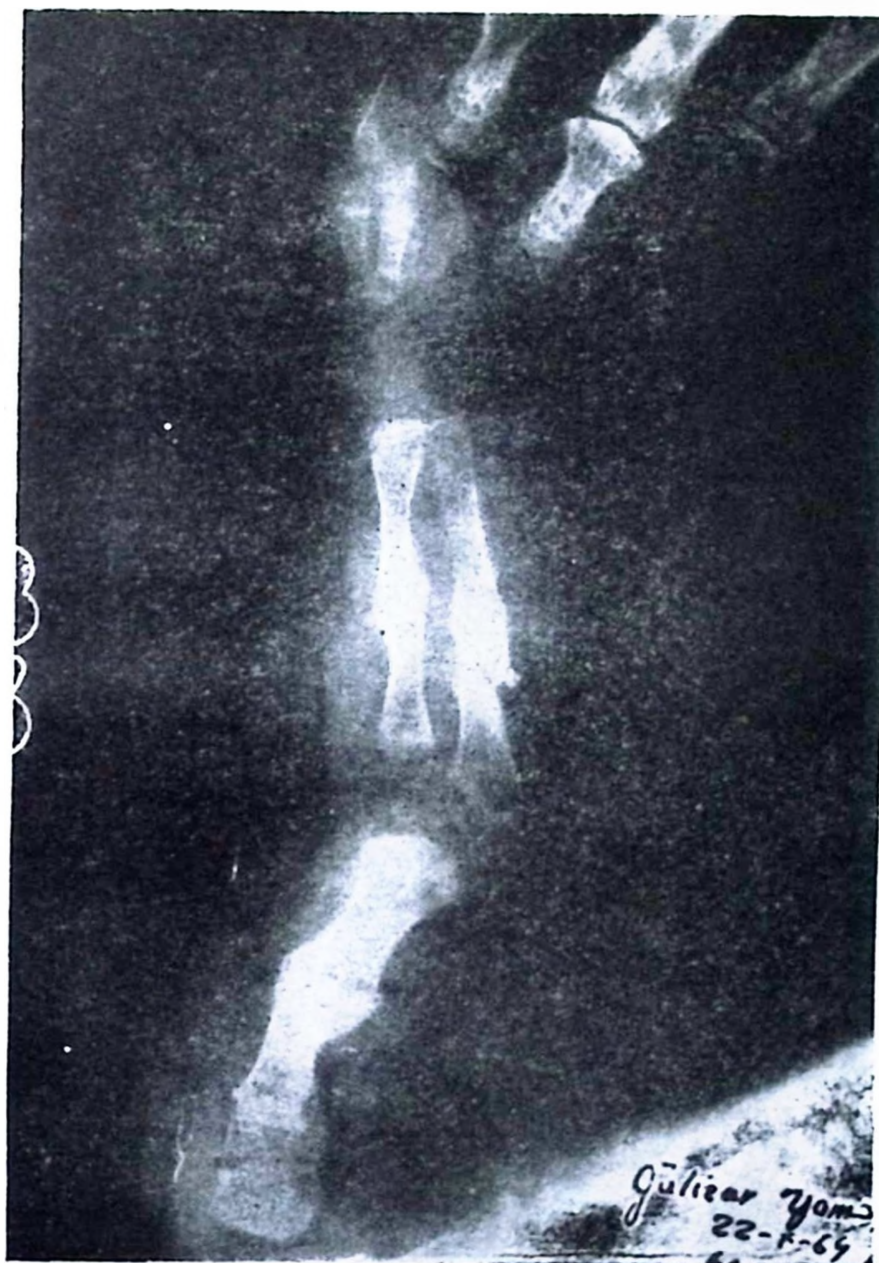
X-ray of the right arm, showing thinning of the cortex, ground glass appearance, and multiple fractures, patient two months old.
